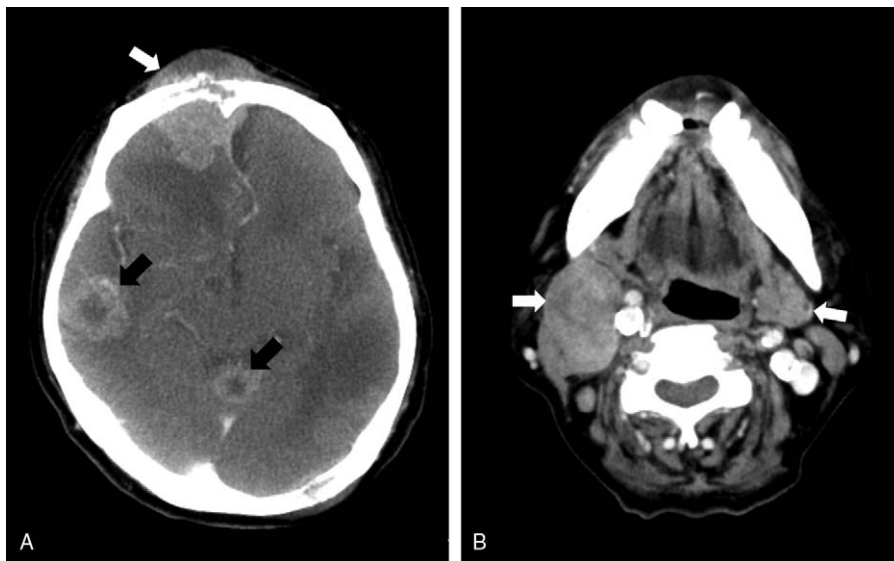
(A) Head computed tomography revealed an osteolytic mass lesion over the frontal bone protruding into the skin and brain (white arrow), with multiple brain metastases (black arrows). (B) Neck computed tomography revealed bilateral neck lymphadenopathy at the right IB-II level and left III level (white arrows).
